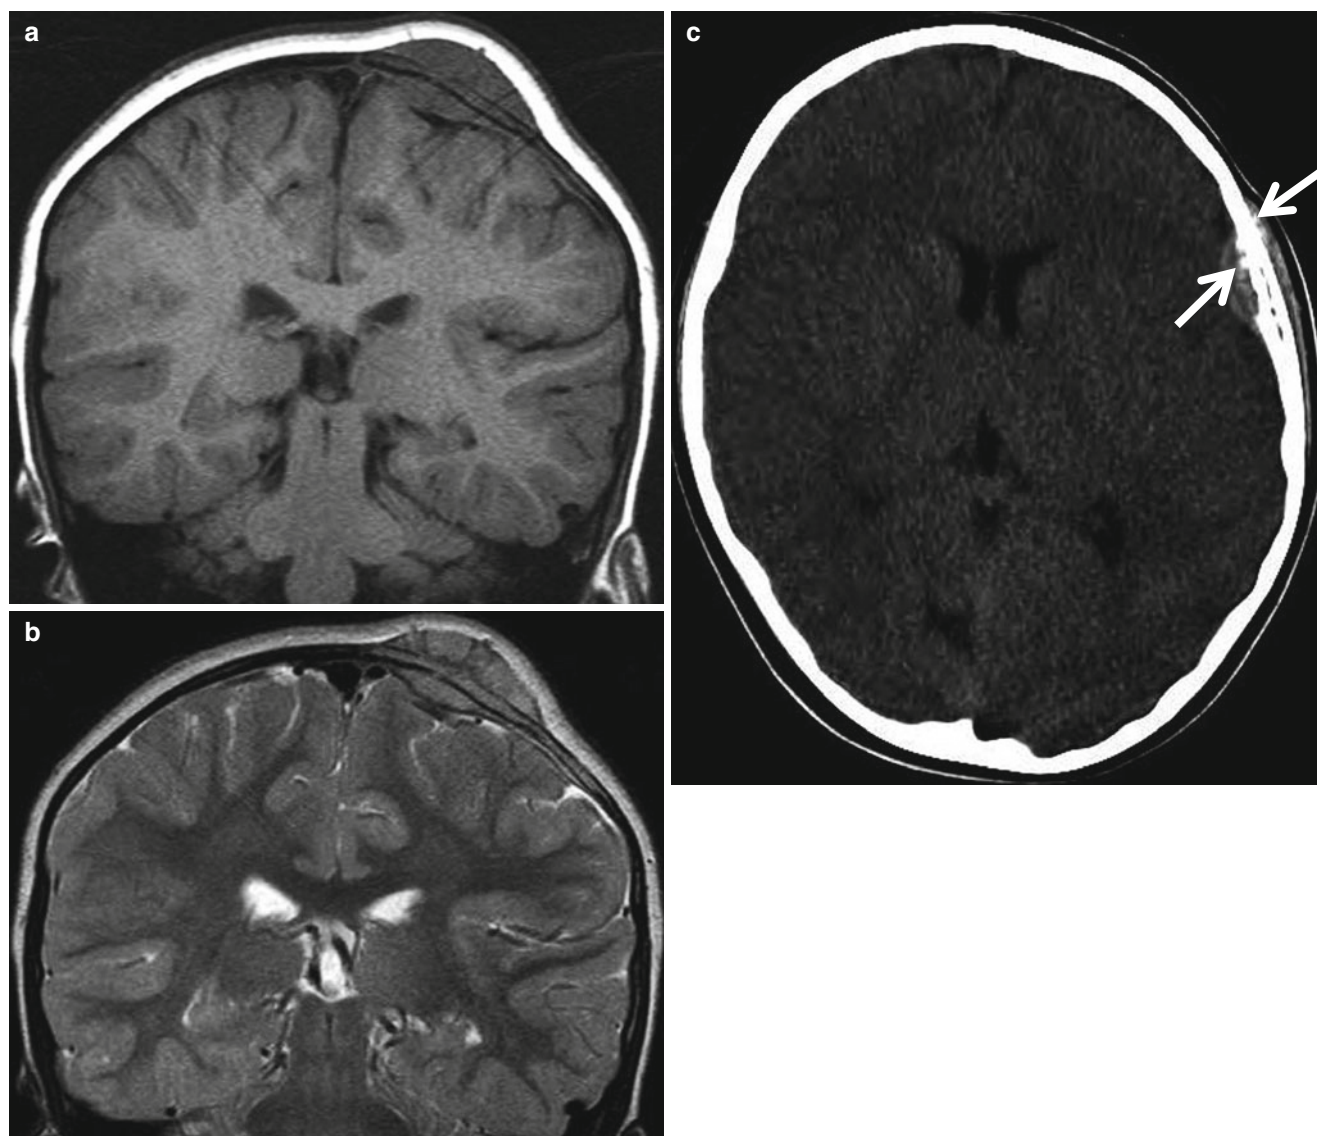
Metastatic neuroblastoma in a 3-year-old boy. (a, b) Coronal T1- and T2-weighted MR images show a calvarial mass involving both epidural and subperiosteal spaces. The mass shows homogeneous
